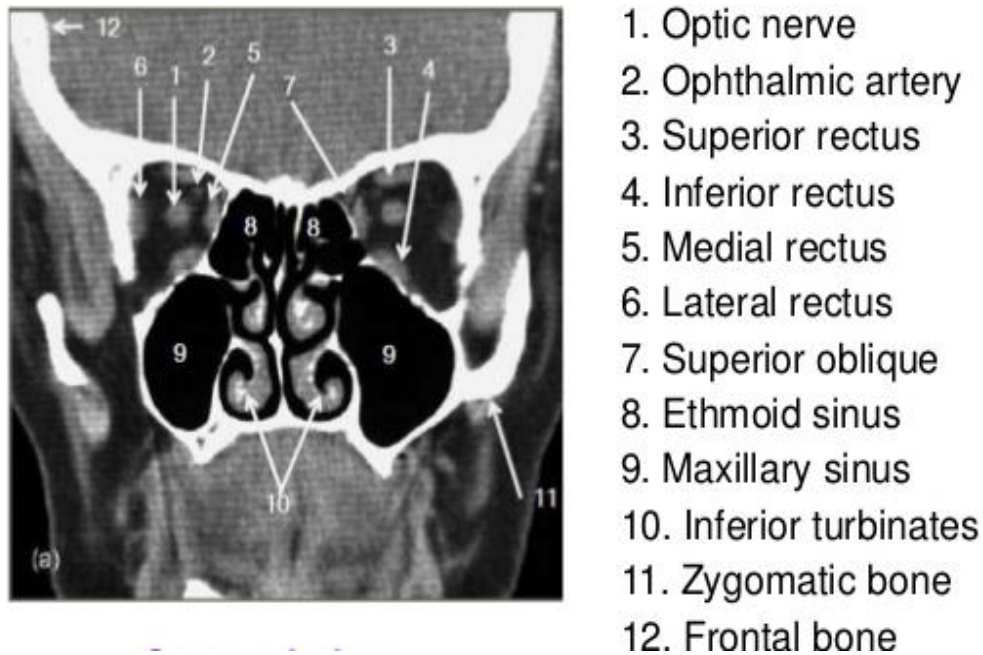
CT Orbit Coronal section
